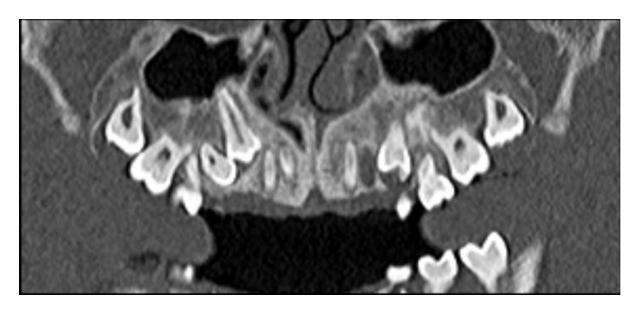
CT Maxilla at age 13 showing an area of idiopathic sclerosis lying between the roots of the 24, 25 and 65.
